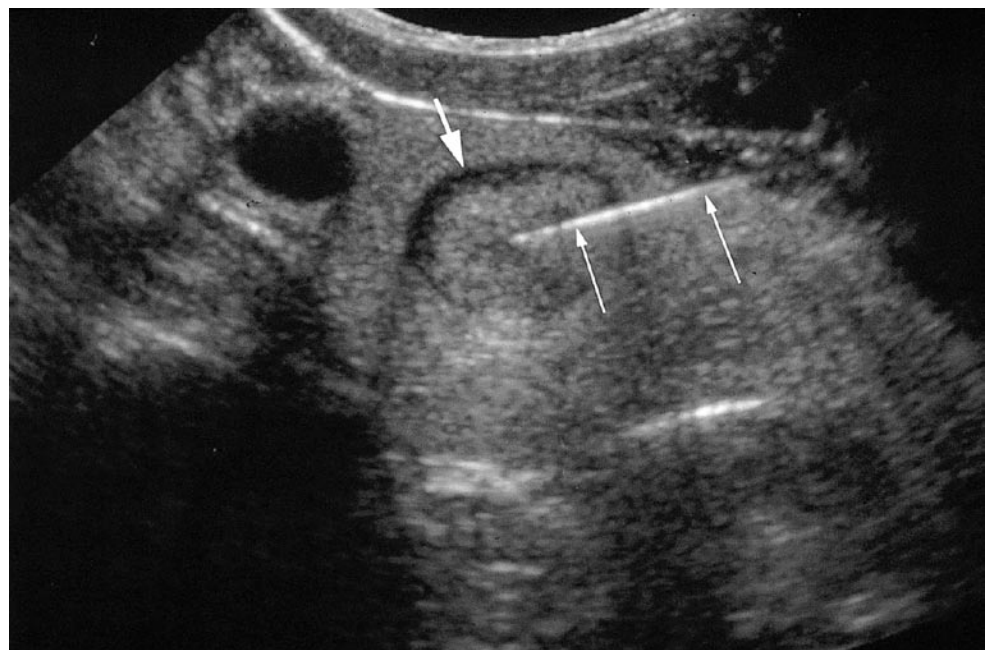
Transverse sonogram of a thyroid nodule. The tip of a needle (*thin arrows*) is in the middle of a nodule (*large arrow*). (Courtesy of Dr. Carol Benson, Brigham and Women's Hospital, Boston.)
